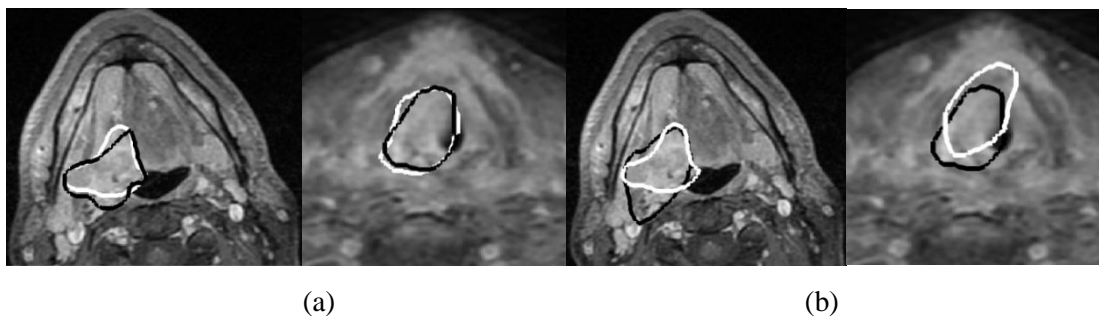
(a) intra- and (b) inter-variability in manual delineation (white and black outline) in GTV of base of tongue (BoT) and larynx tumours from MRI (Courtesy of The Beatson West of Scotland Cancer Centre, Glasgow)
